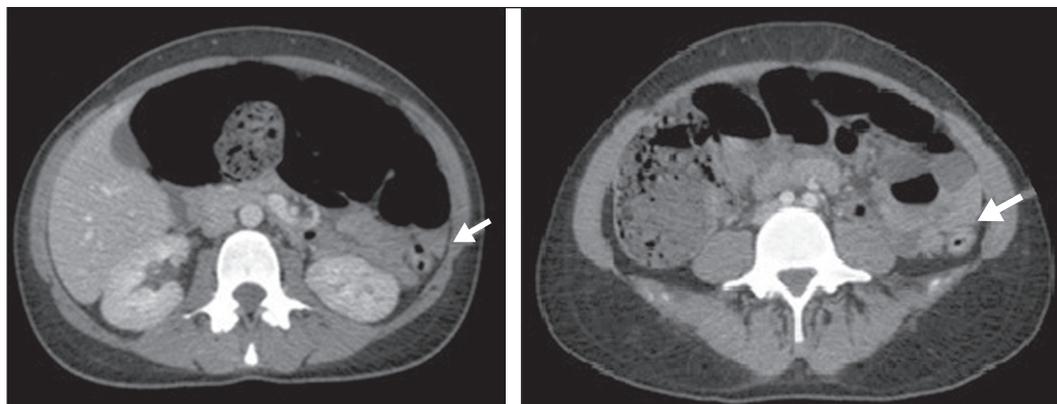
CT scan of the abdomen, in axial sections, obtained 60 s after injection of iodinated anionic contrast. Note the intestinal obstruction at the level of the proximal descending colon, adjacent to the splenic flexure. Distension of the transverse colon, ascending colon, and cecum, with the presence of fecal matter. The transitional zone can be seen at the level of the splenic flexure (arrow), with no evident obstructive material.
